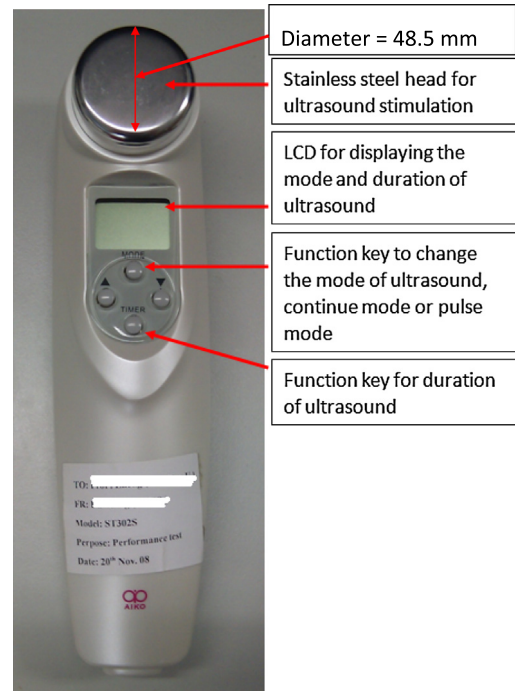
A picture of the ultrasound stimulation device. The use of various parts of the device as seen in the front view was briefly introduced.
